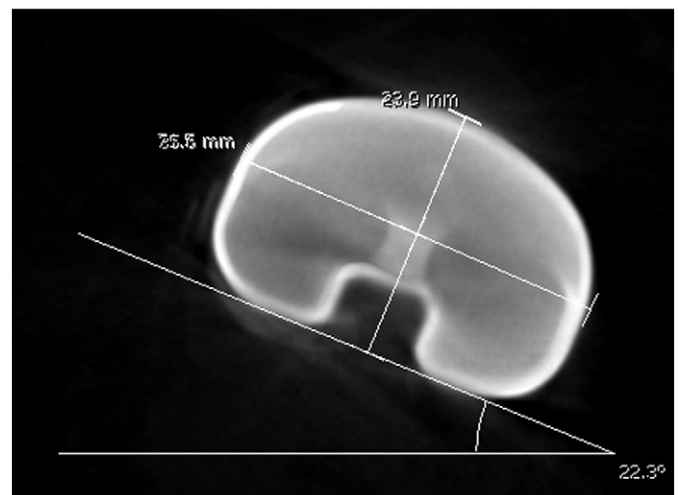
Axial CT image of an example tibia displaying the lines representing the posterior condylar axis and the tibial implant orientation (with measurements).
